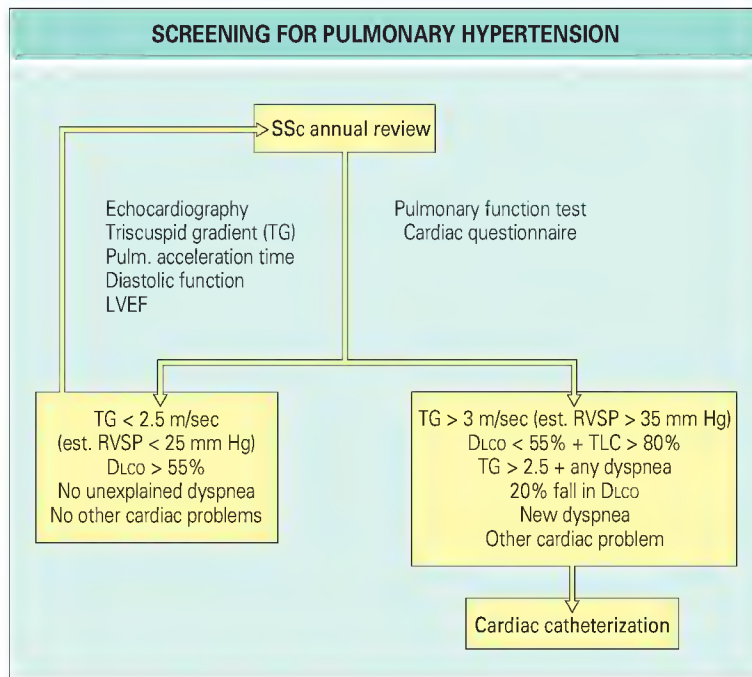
Annual screening for the development of pulmonary hypertension is vital in managing systemic sclerosis (SSc). Currently, a combination of symptomatic assessment, Doppler echocardiography, and pulmonary function testing is employed with the need for right-sided heart catheterization depending on the results of these investigations. DLco, diffusion capacity for carbon monoxide; est., estimated; LVEF, left ventricular ejection fraction; Pulm., pulmonary; RVSP, right ventricular systolic pressure; TLC, total lung capacity.
